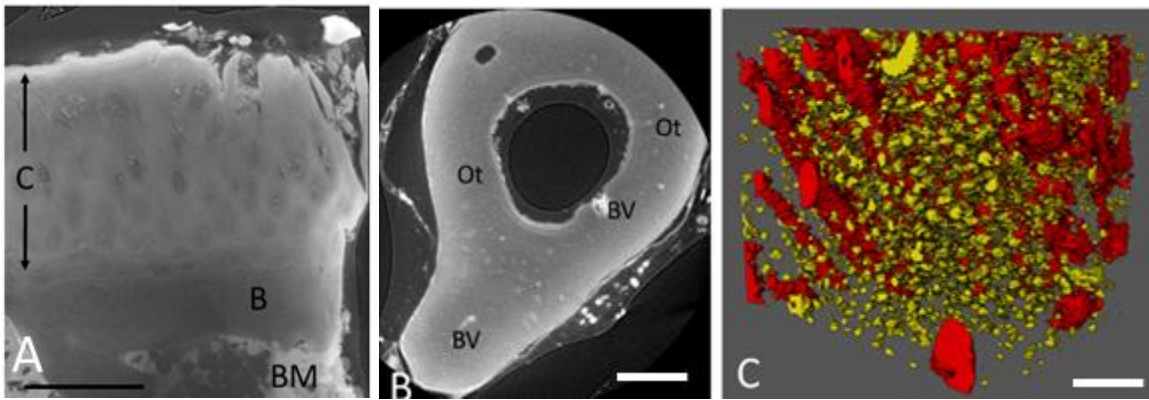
μ CT data – identification of microstructure and segmentation
